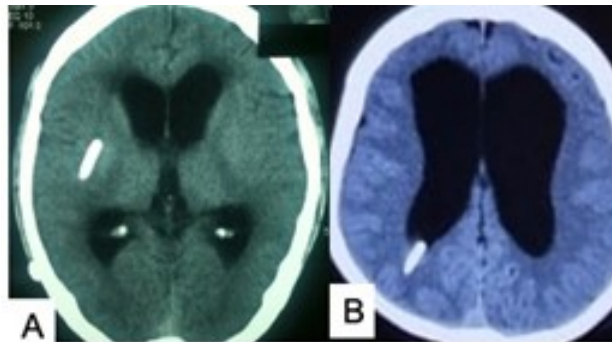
(A) CT scan showing that the cranial end of the VP shunt is not in the ventricle; (B) CT scan showing that the cranial end of the VP shunt has migrated out of the ventricle. Source: Figure by authors.
